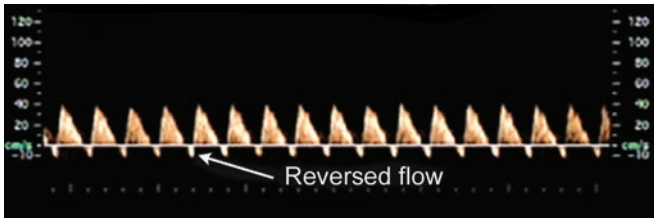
Reversed flow on Doppler analysis
